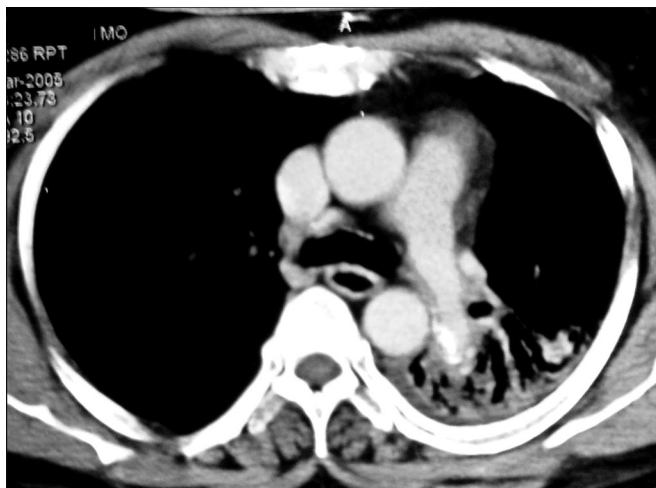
Posttreatment CT scan of thorax (axial section).
